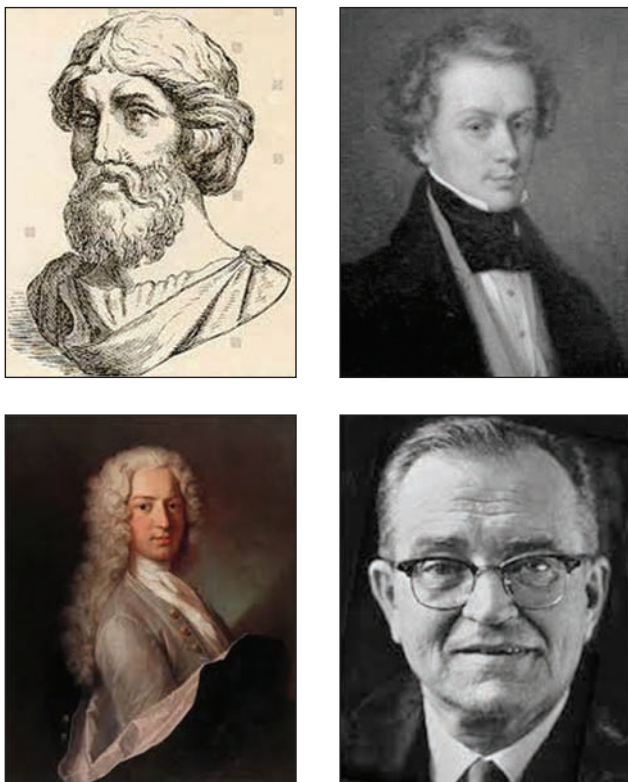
Pythagoras, Doppler, Bernoulli, Dussik. The Ancient Warriors of Science and One New
